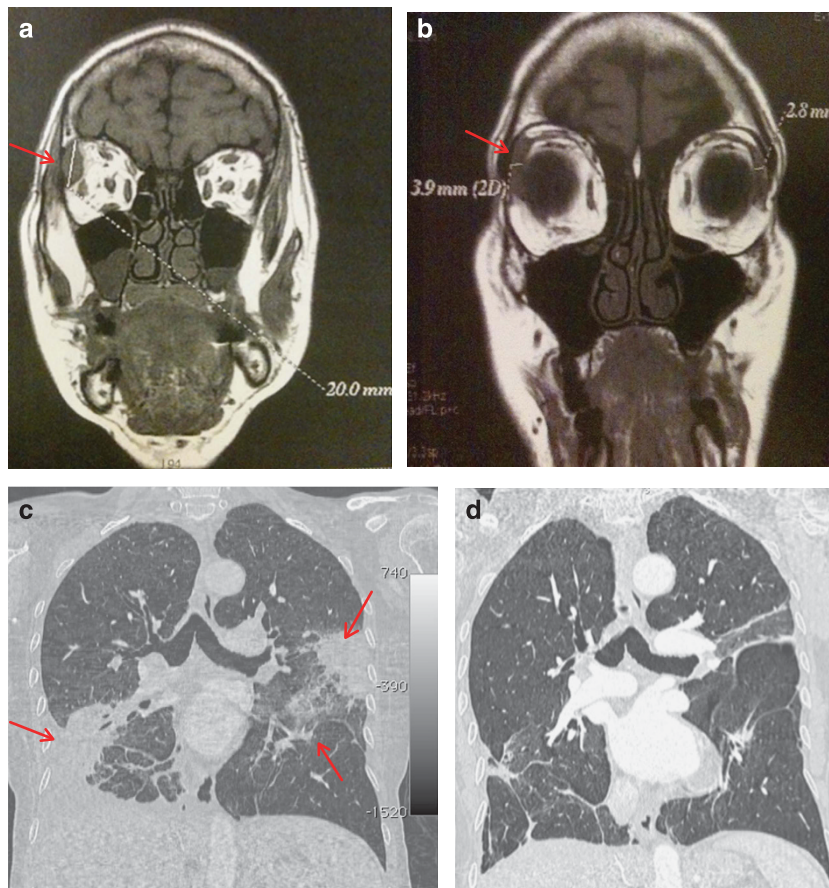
MRI showing the lacrimal gland before (a) and after (b) breast implant removal. A substantial decrease in size was observed. The lung scan shows a triangular, pleura-based opacity, and ground-glass opacities before implant removal (c) and a few months later (d). The opacities have almost completely disappeared.
